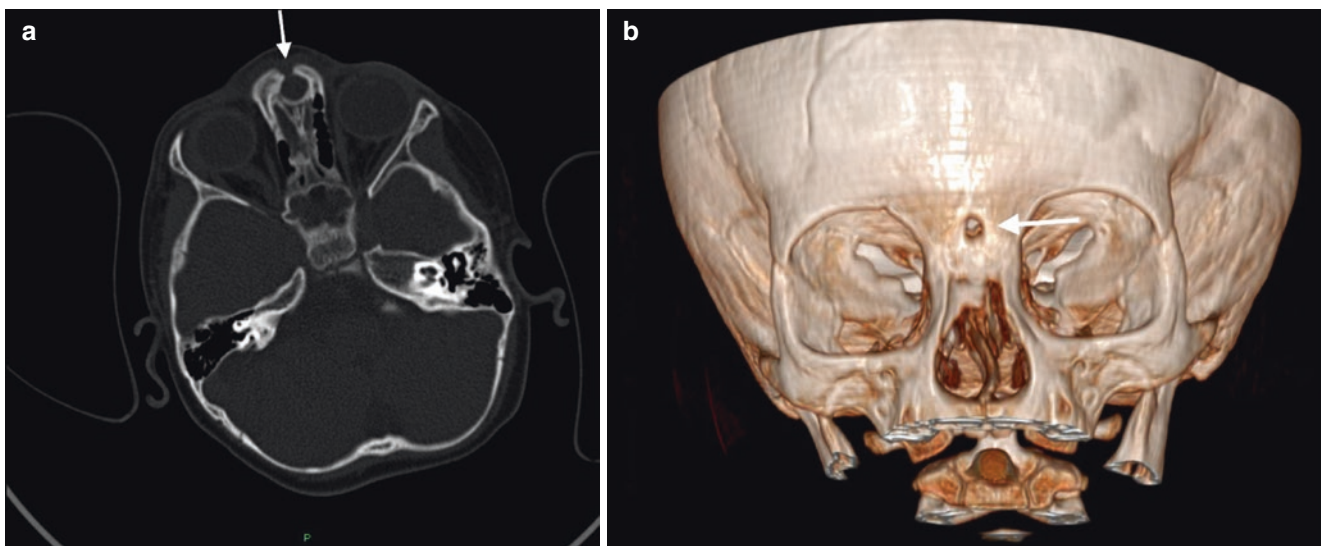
Axial CT (a) and frontal view of 3D reformation (b) show a small, midline bony deficiency in the nasal bone (*arrow*) due to a nasal dermoid tract. An enlarged foramen cecum is seen posterior to the bony deficiency on the axial image
